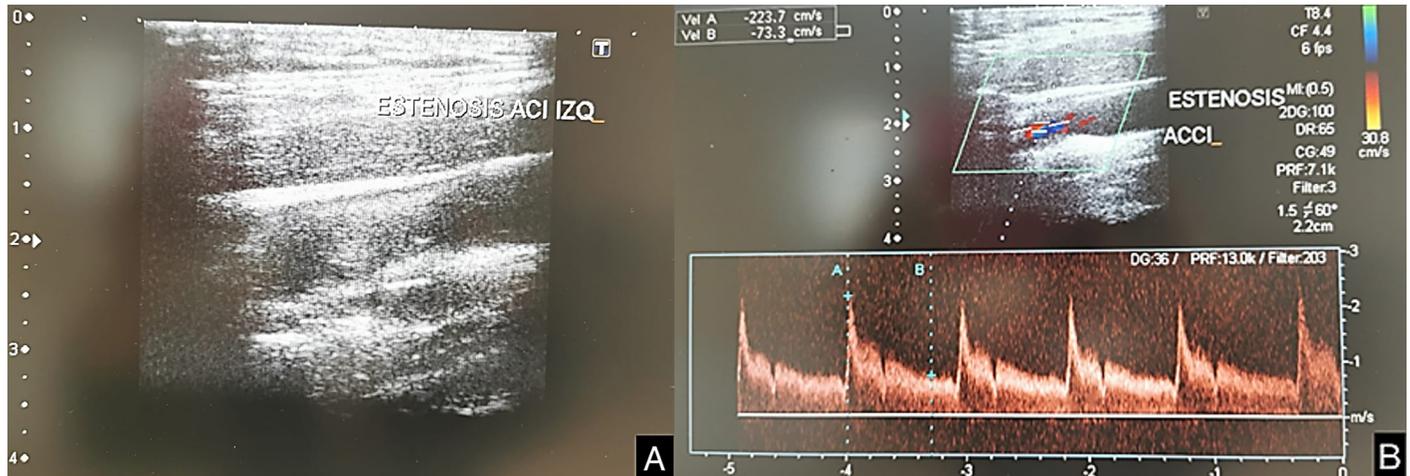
A) US of the left common carotid artery (LCCA) and left internal carotid artery (LICA) showing significant obstruction of its lumen. B) Doppler US of the LICA with significant velocities
